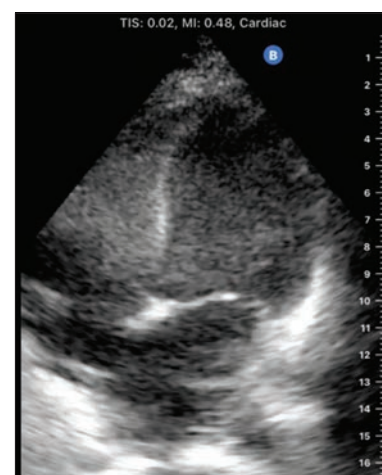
Dilatation of left ventricle as seen from an apical four-chamber view.
